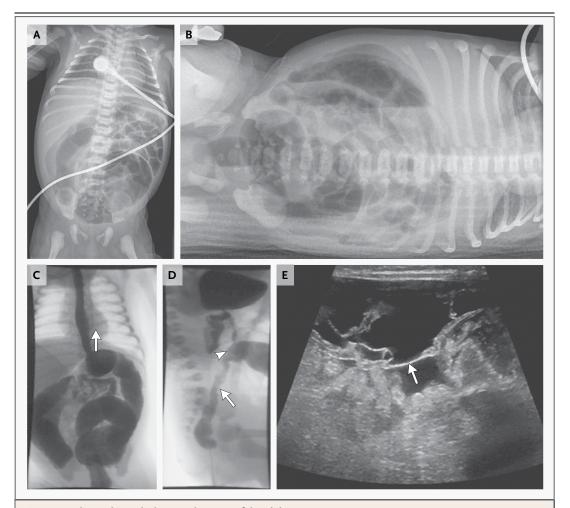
Radiographic and Ultrasound Images of the Abdomen.
